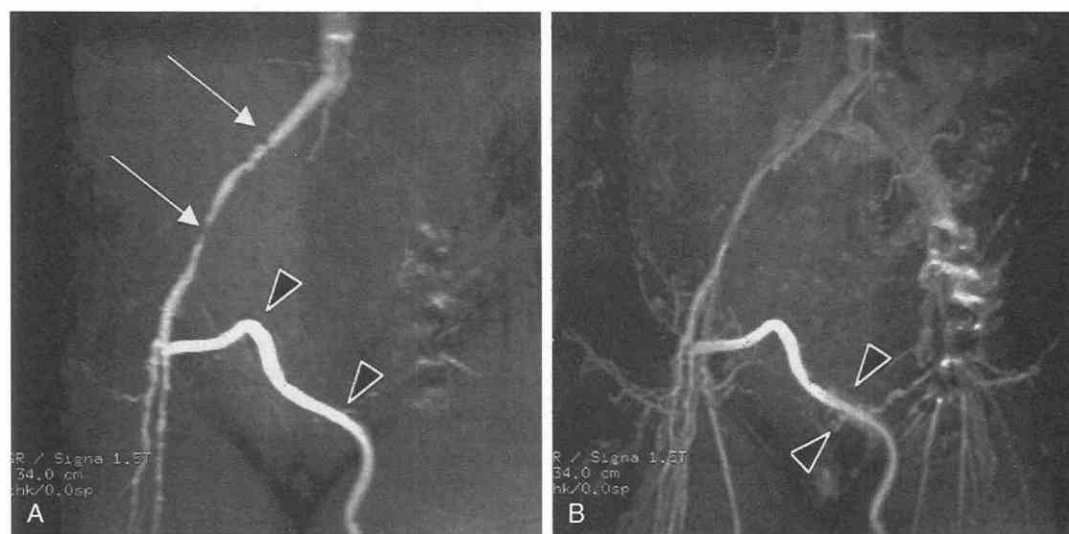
Infected femoral graft and venous thrombosis in a 73-year-old woman, shown by gadolinium-enhanced, 3D gradient-echo imaging. *A*, Projection reconstruction of a coronal slab from a gradient-echo sequence (TR = 13 msec, TE = 2.3 msec) shows a completely occluded left iliac arterial system. The right arterial system is severely diseased with multiple stenoses (arrows). A patent cross-graft femoral-to-popliteal graft is seen (arrowheads). *B*, Venous phase of the 3D technique shows focal enhancement around the graft (arrowheads), which proved to represent infection in the graft. Numerous collateral veins from bilateral iliac venous occlusions can be seen. (From Outwater EK: Ultrafast MR imaging of the pelvis. *Eur J Radiol* 29:233-244, 1999.²⁵⁵)
